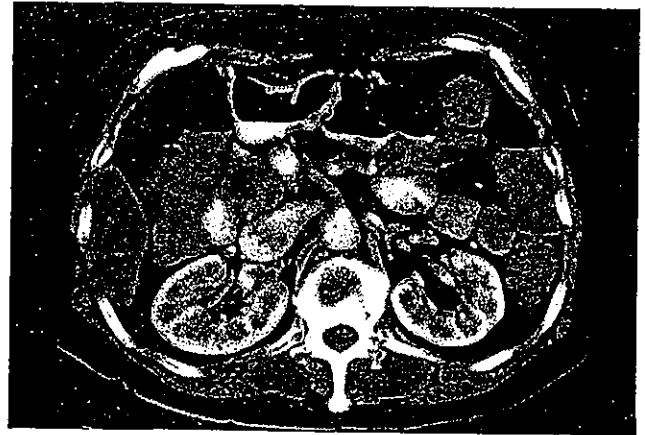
Computed tomography in the patient's mother demonstrates a pancreatic head mass, 3 cm in diameter
